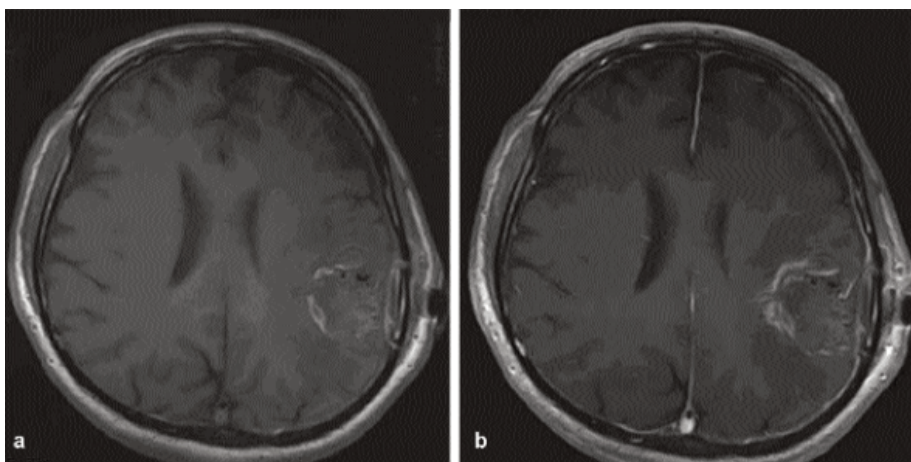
(a,b) Post-operative MRI T1W pre and post-contrast axial images, showing gross total resection of GBM.
